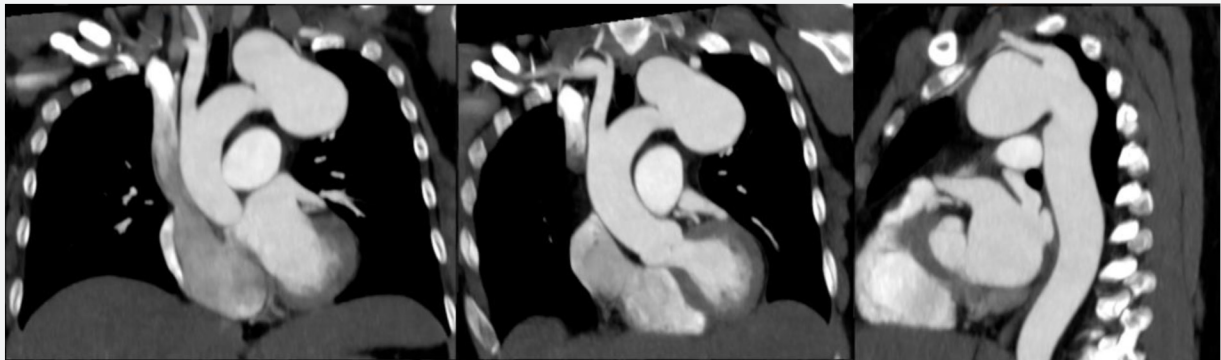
B. CTA demonstrating the large saccular, lobulated, aortic arch aneurysm arising between the left common carotid and left subclavian artery. Figure 1C. Image showing the saccular lobulated aneurysm just before the takeoff of the left subclavian artery (LSA) which appears widely patent and tortuous.
